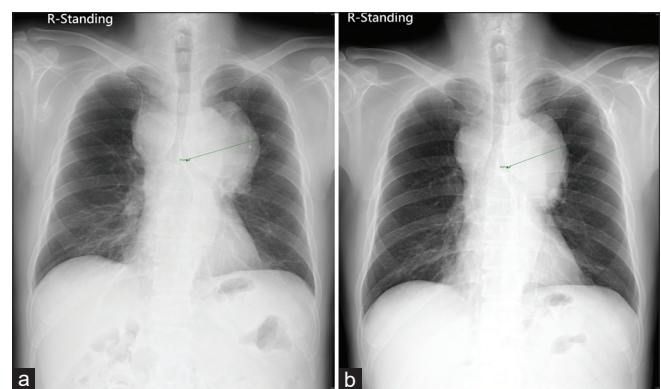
(a) Chest X-ray before receiving afatinib; the mass was bulging and compressed the left bronchus. (b) The mass was more flattened and had significantly decreased in size (from 75 mm to 60 mm)
